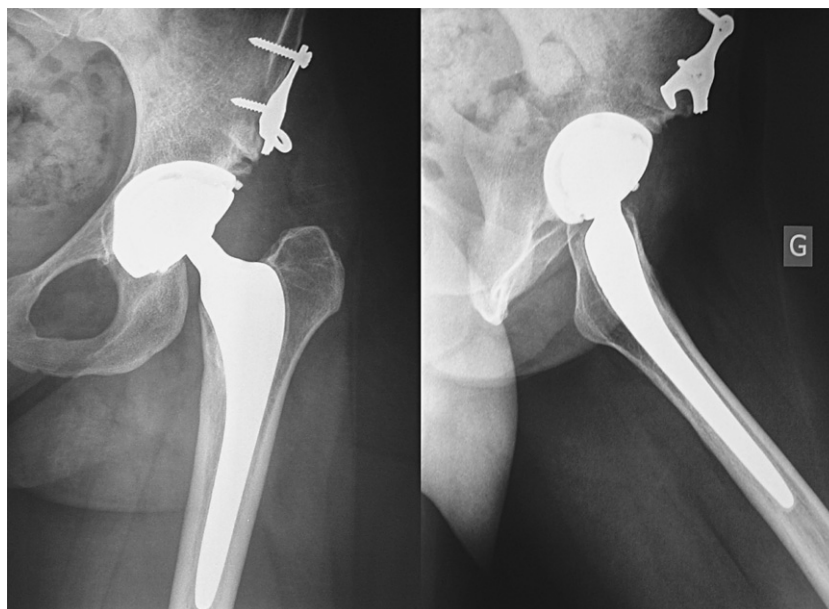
Radiographs revealing neither bearing surface anomaly nor osteolysis around the non-cemented Plasmaceram™ bearing surface prosthesis.
